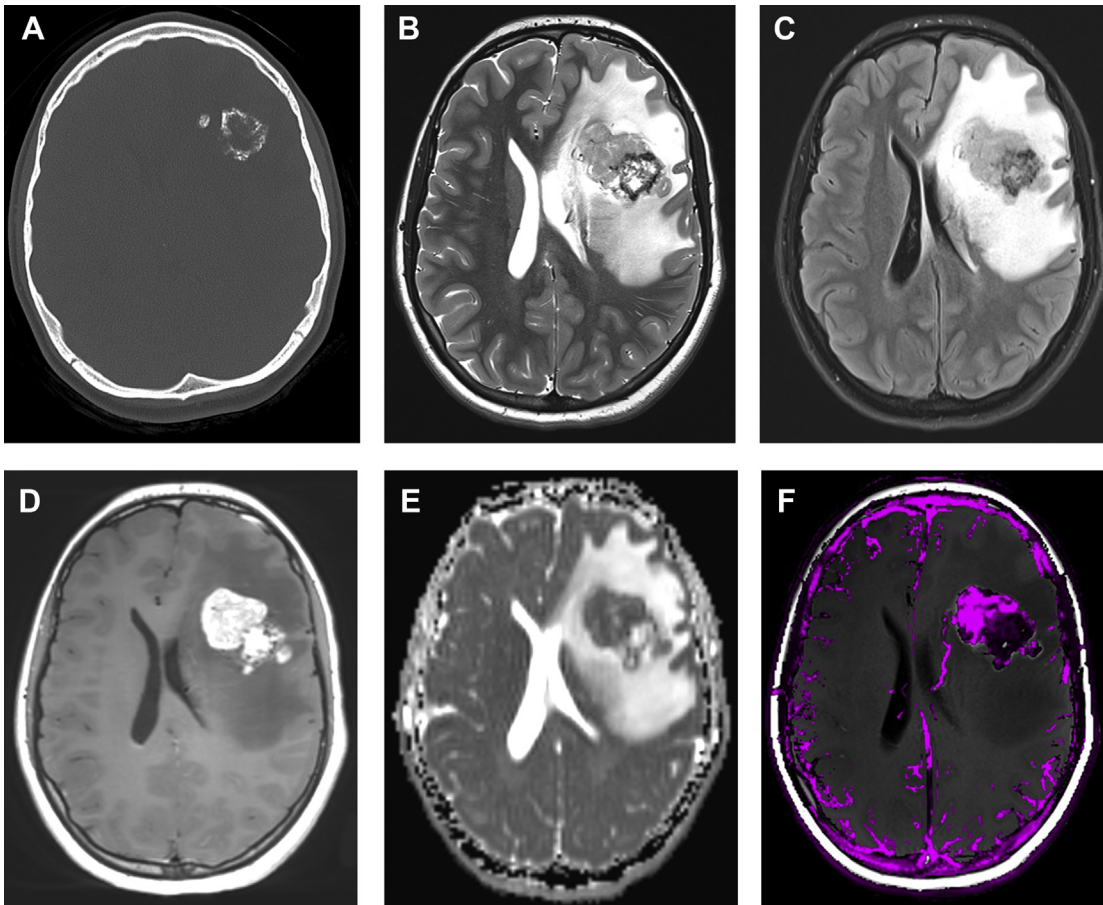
A 16-year-old girl with 1 month of headache due to a brain tumor. Axial CT (A) and T2-weighted (B), FLAIR (C), postgadolinium 3D T1-weighted spin-echo (D), apparent diffusion coefficient map (E), and post-processed dynamic contrast-enhanced perfusion (F) MR images show a partially calcified, enhancing intra-axial tumor with low diffusivity, elevated blood flow, extensive surrounding vasogenic edema, and mild mass effect. The resected lesion represented anaplastic ganglioglioma.
